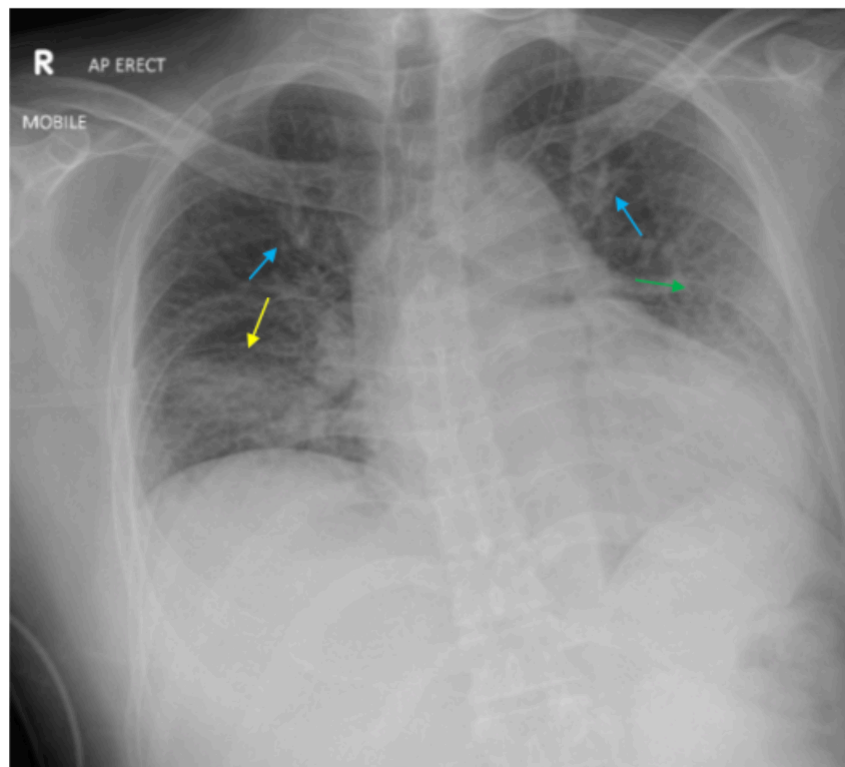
Chest X-Ray (CXR) showing bilateral pulmonary parenchymal opacification in the right lower zone (yellow arrow) and the left mid zone (green arrow) with upper lobe pulmonary venous diversion (blue arrows) consistent with pulmonary oedema. R, right.
